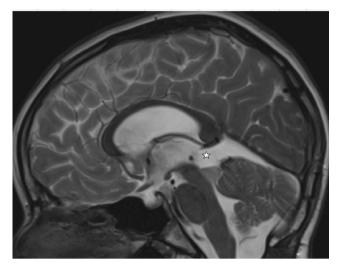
Preoperative axial and sagittal T1-weighted MR-image with contrast showing the partly contrast enhancing hypointense lesion (*star*) of the quadrigeminal plate and bilateral thalamic involvement
